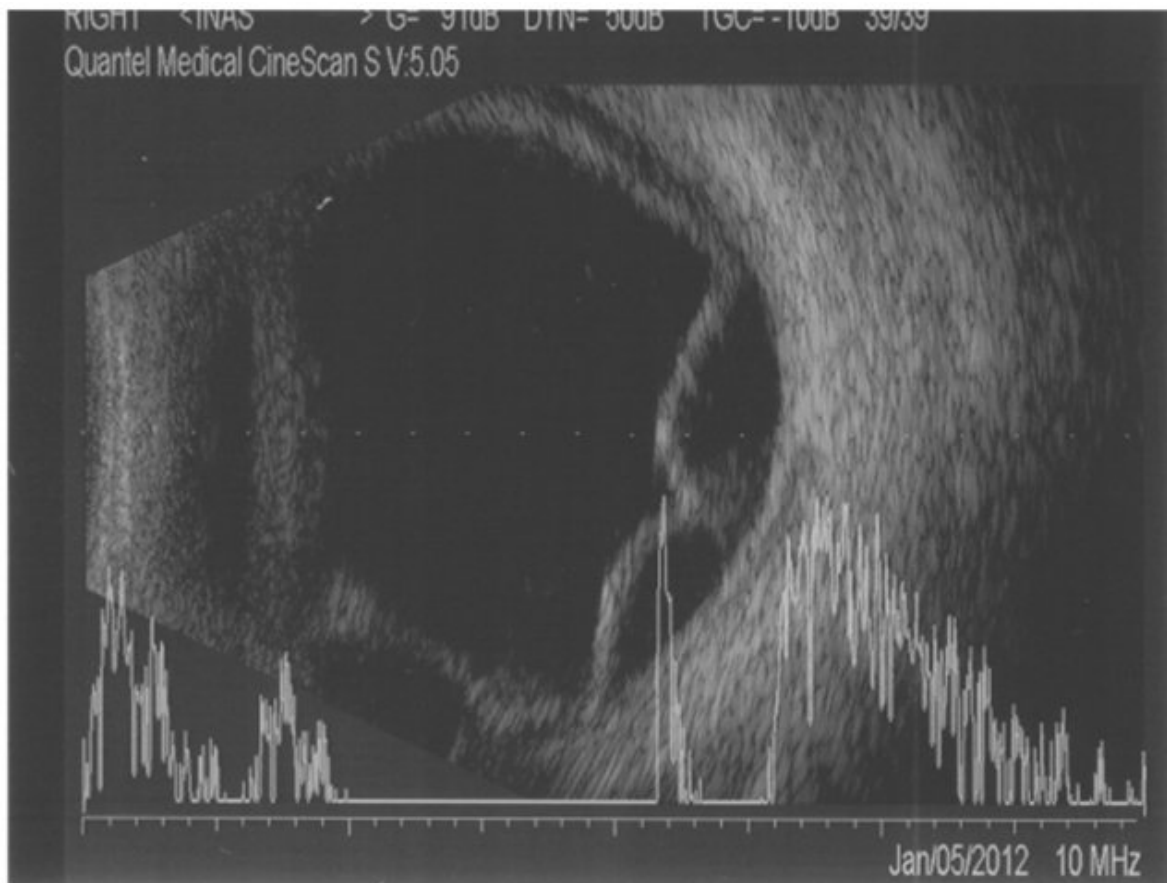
An ultrasound image showing chorioretinal detachment and an impressive choroidal effusion. [57]
